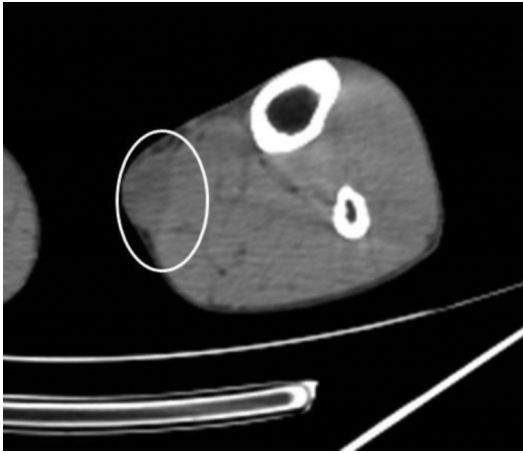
Lower-extremity noncontrast, low-dose axial CT image of lower extremities demonstrates 2.9 x 1.8 x 3.7-cm soft-tissue mass along medial aspect of left calf within the superficial subcutaneous soft tissues. The longest diameter in the coronal plane is 3.6 cm, in the sagittal plane 3.6 cm, and in the transaxial 3.2 cm.
